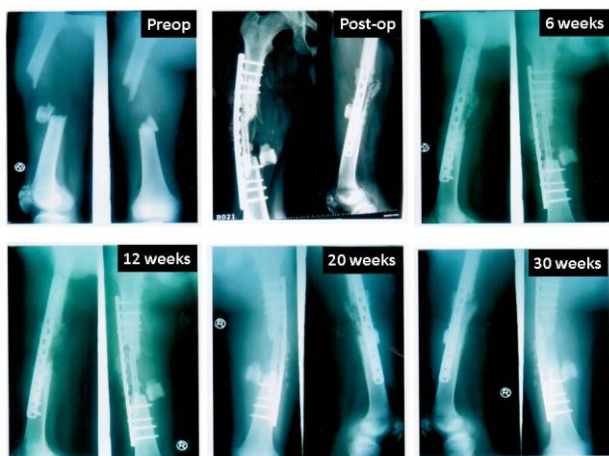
Radiographs of a patient with a bone gap ~1 inch.
